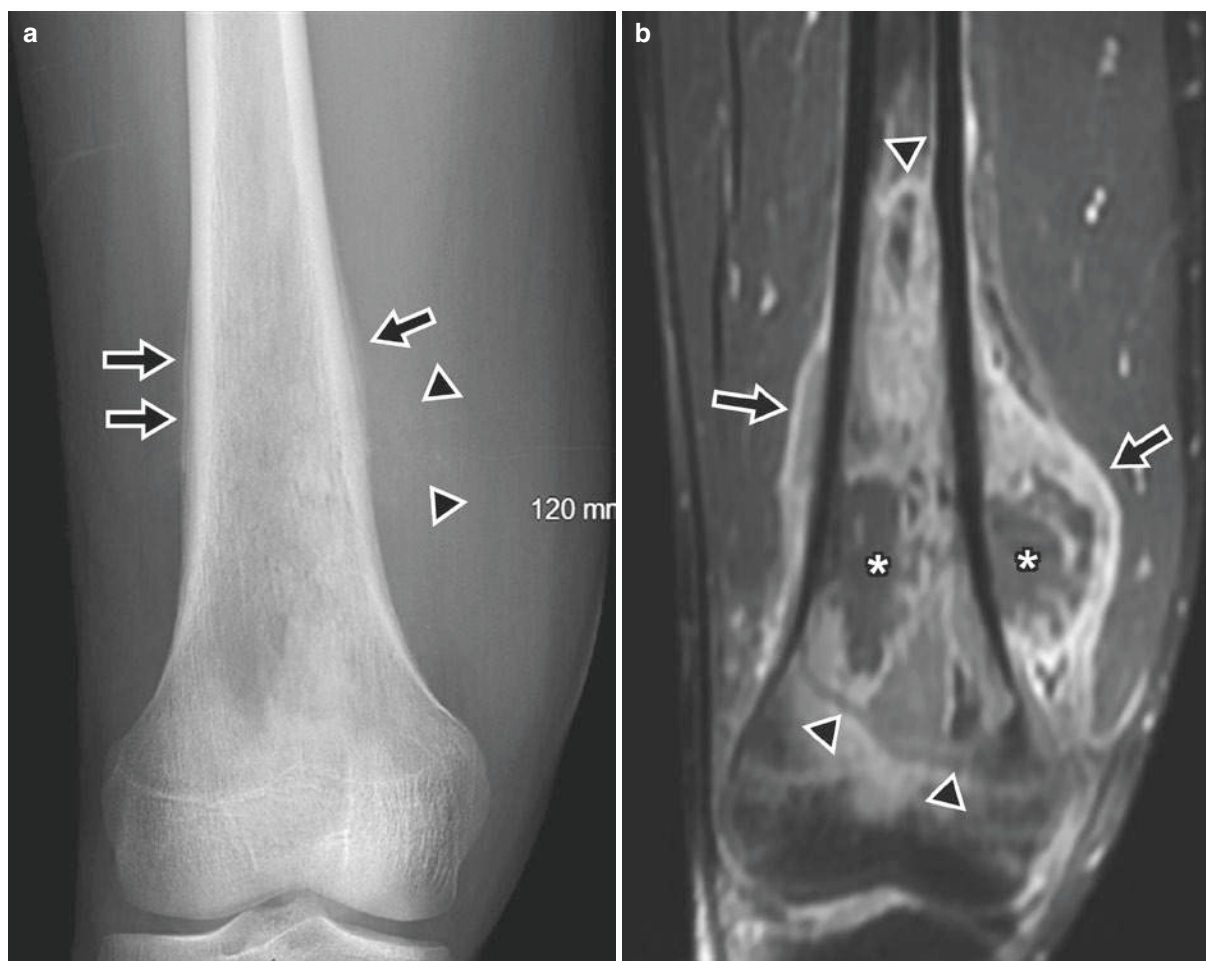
15-year-old boy with osteosarcoma of the distal femur. (a) Anteroposterior radiograph shows an ill-defined mixed lucent and sclerotic lesion in the distal femoral metaphysis and diaphysis. Periosteal new bone (arrows) is mildly irregular. Faint opacities project in soft
